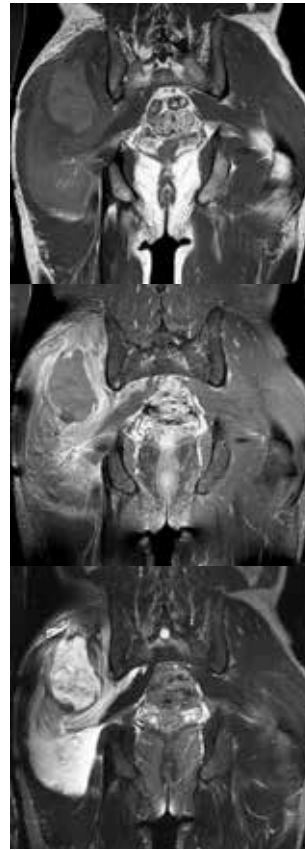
demonstrated MRI coronal T1W, T1W with Gd and T2W fat suppression view respectively.
